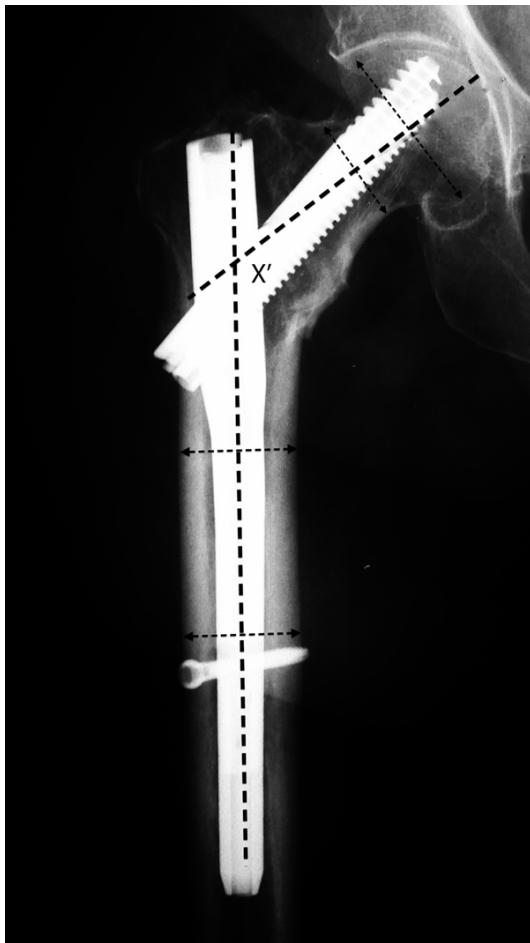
Varus collapse over the INTERTAN nail is seen in late postoperative roentgenogram. Neck shaft angle (x') between the dashed lines is measured.
